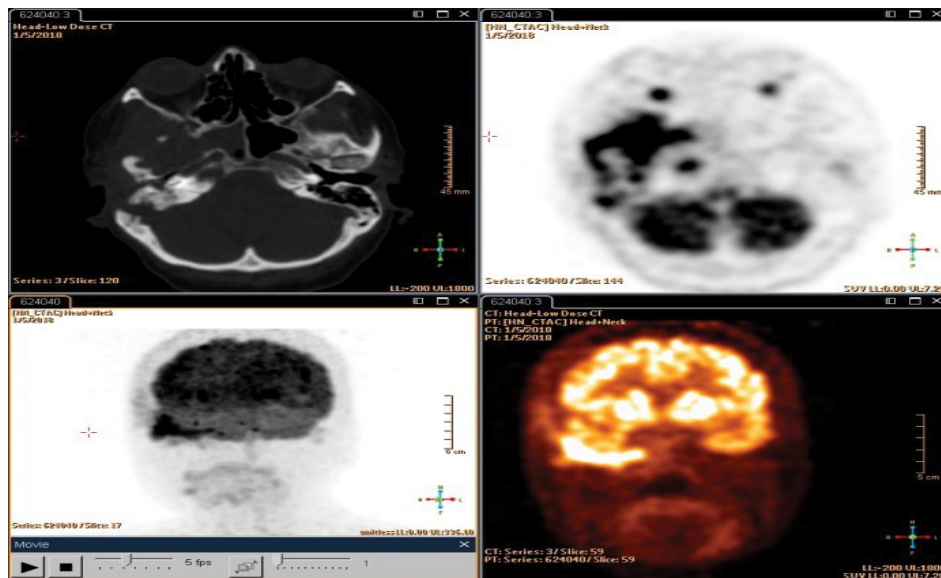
PET\CT revealed multiple soft tissue density lesions involving left mandibular, left side of occiput, sphenoid bone, zygomatic bone, lateral wall of right orbit, right maxillary and right temporal bone.
